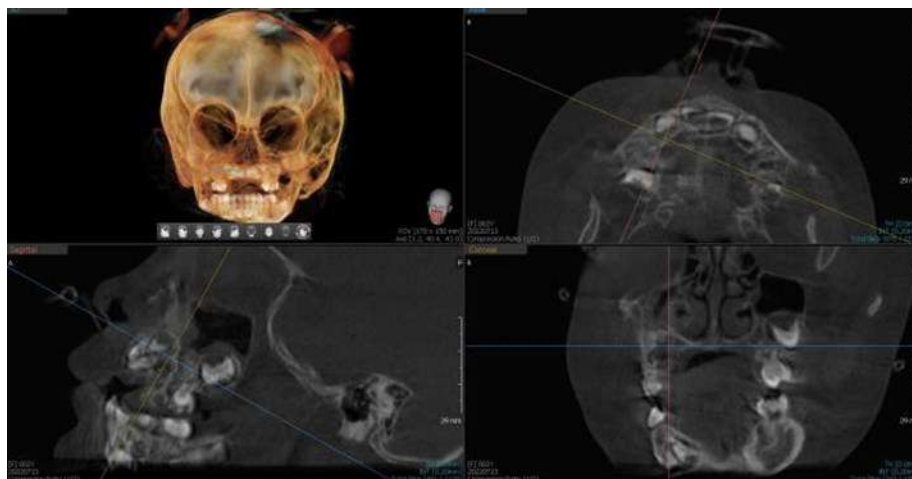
CBCT images of a 2 year old patient under general anesthesia, show hypodense area in #53 extending to the right maxillary sinus
